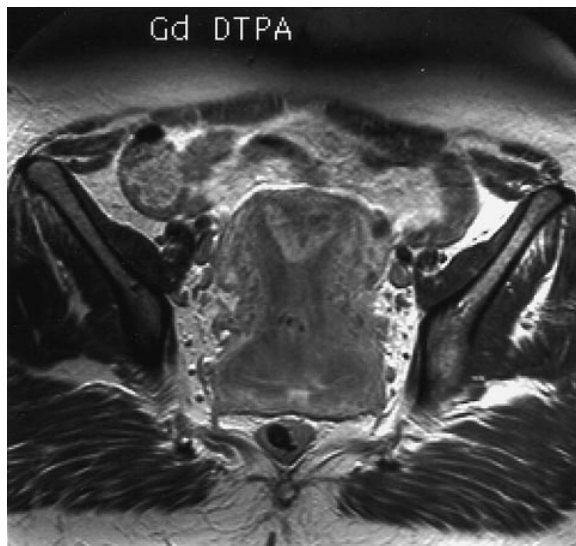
MRI scan of the pelvis using a T_1 weighted post-contrast sequence in the paracoronal plane. A congenital septate uterus is clearly shown in addition to the large tumour mass.
